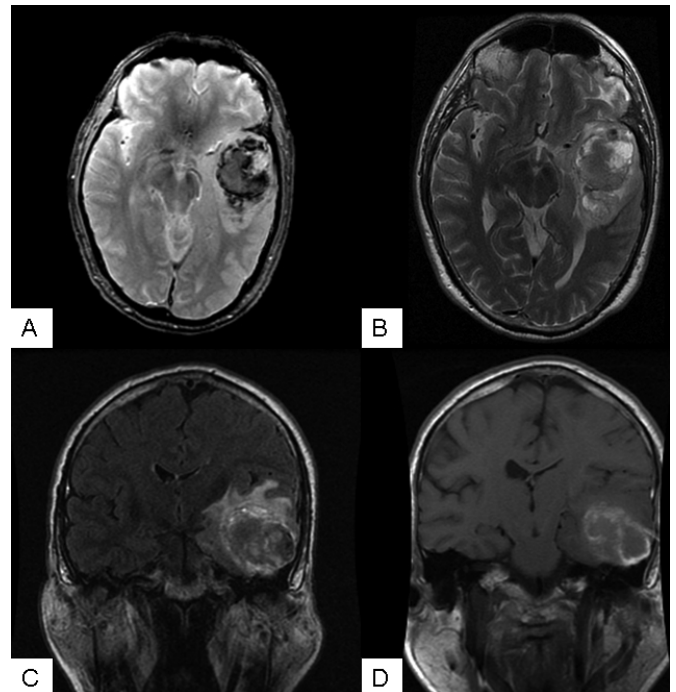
MRI imaging demonstrating a left temporal lobe intracranial hemorrhage with an underlying gadolinium-enhancing mass lesion. A. gradient echo; B. T2; C. FLAIR; D. T1 with gadolinium.
